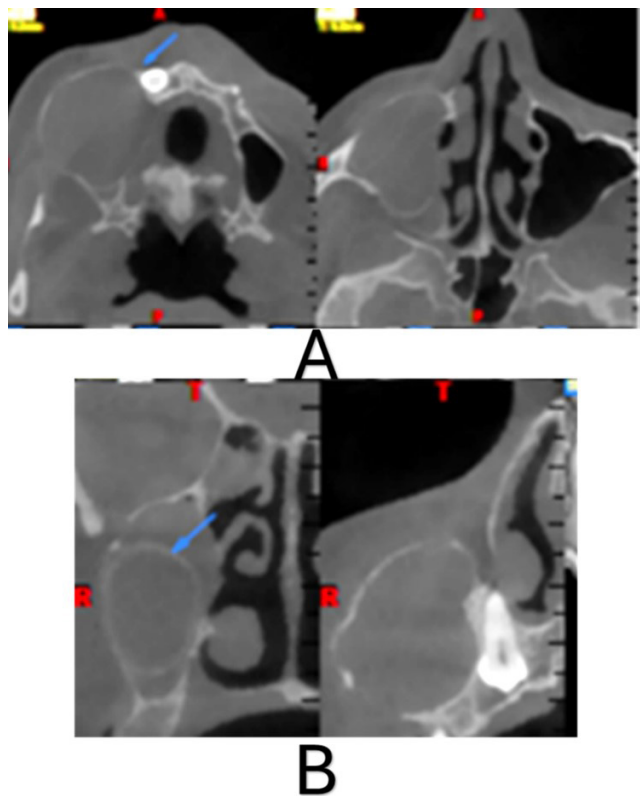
(A and B): CBCT scans showing destruction on buccal and lingual cortex, with well-defined radiopaque lesion on the right maxillary sinus region.
